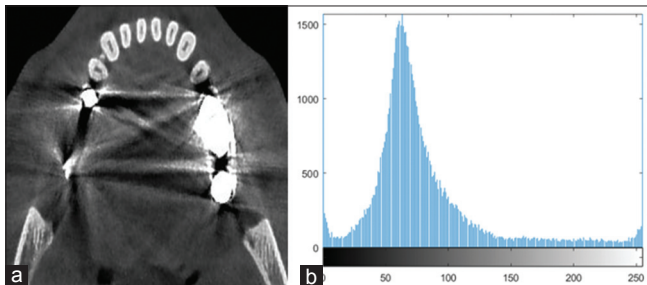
Cone beam computed tomography dental image and its histogram (a) dental cone beam computed tomography image, (b) related histogram
